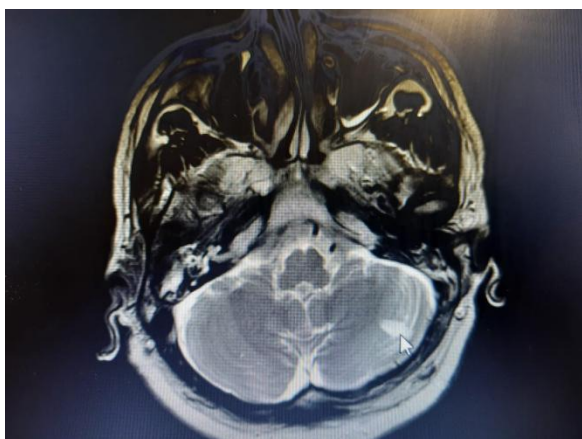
MRI in a patient with vertigo showing acute cerebellar infarct.
